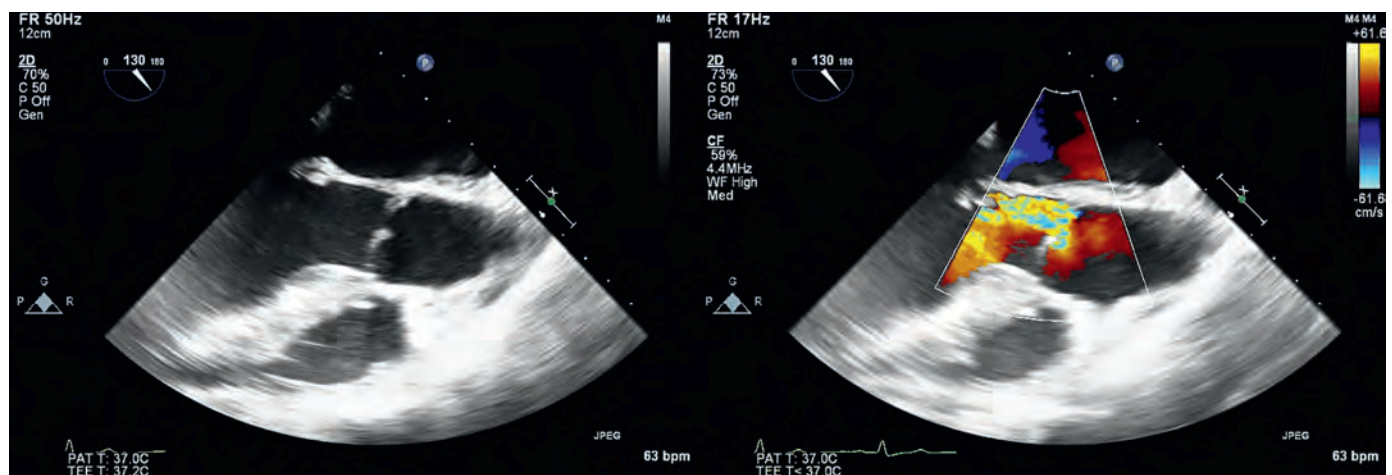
Type III aortic regurgitation. (Left) Although the midesophageal aortic valve long-axis view reveals a normal anterior right coronary cusp, the more posterior cusps (left and noncoronary) are small and retracted. This retraction results in a large defect in the aortic valve. (Right) Addition of color-flow Doppler reveals a large regurgitant jet beginning at the posterior aspect of the aortic valve, which continues along the posterior wall of the left ventricular outflow tract. (Video available online.)
